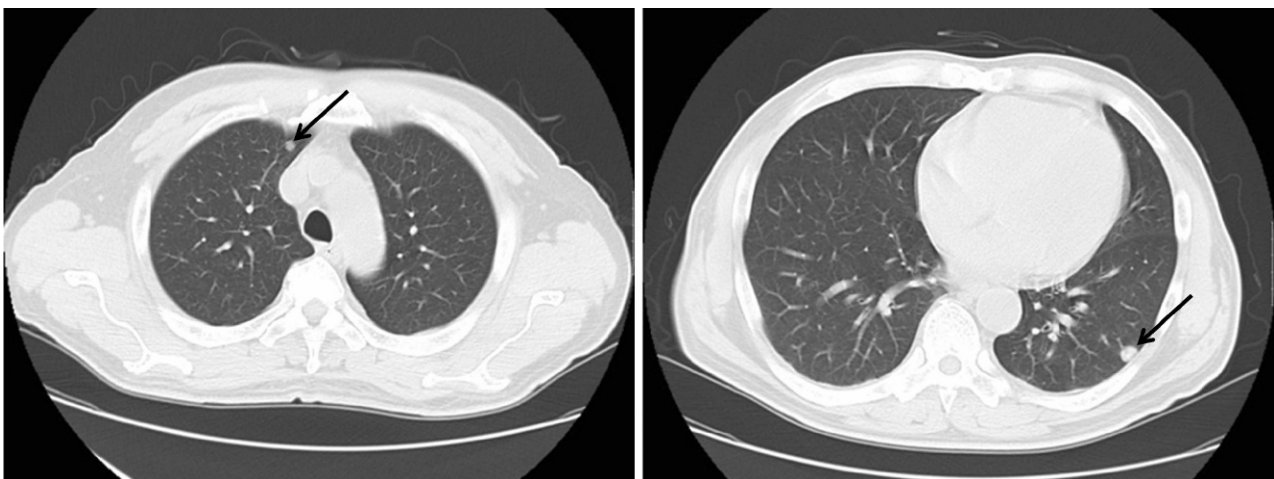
Chest CT showed a tumor (arrows) in each of the lungs.
